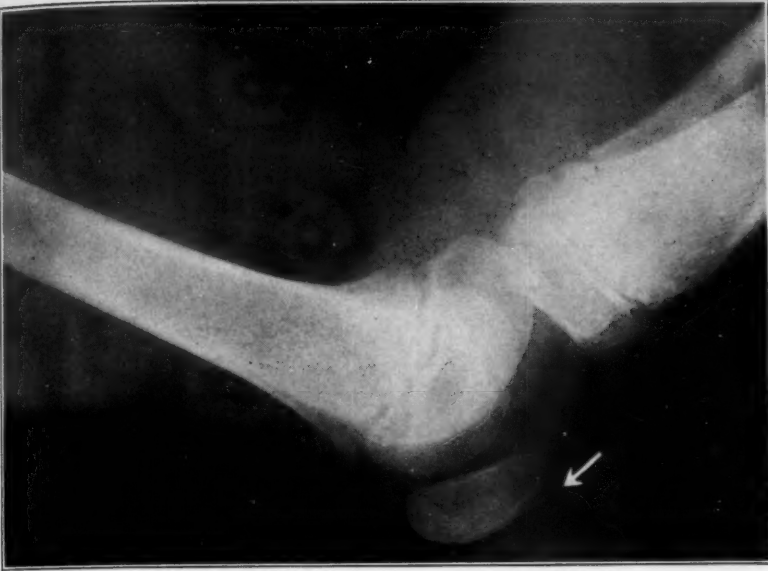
Roentgenogram of the right knee (Lucille).
